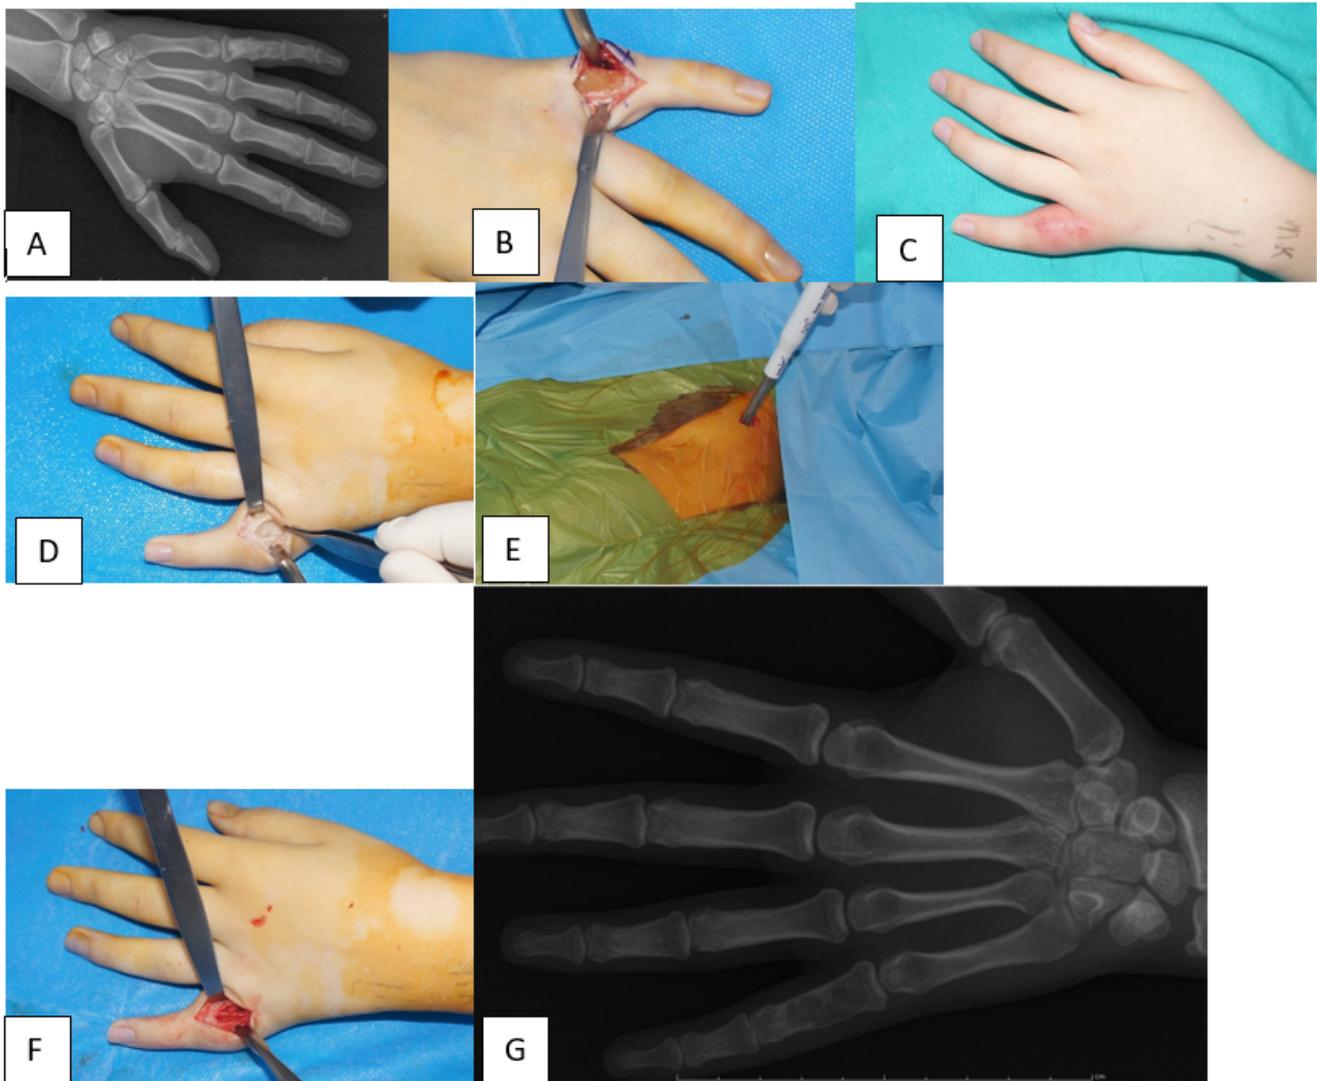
(A) LGCS in the fifth proximal phalanx. (B) Putty after curettage. (C) Inflammatory reaction after 1 month due to putty DBM . (D) Debridement. (E) Percutaneous iliac autograft harvesting with a mosaicplasty blade. (F) Autograft settled to the defect properly. (G) Postoperative x-ray.
